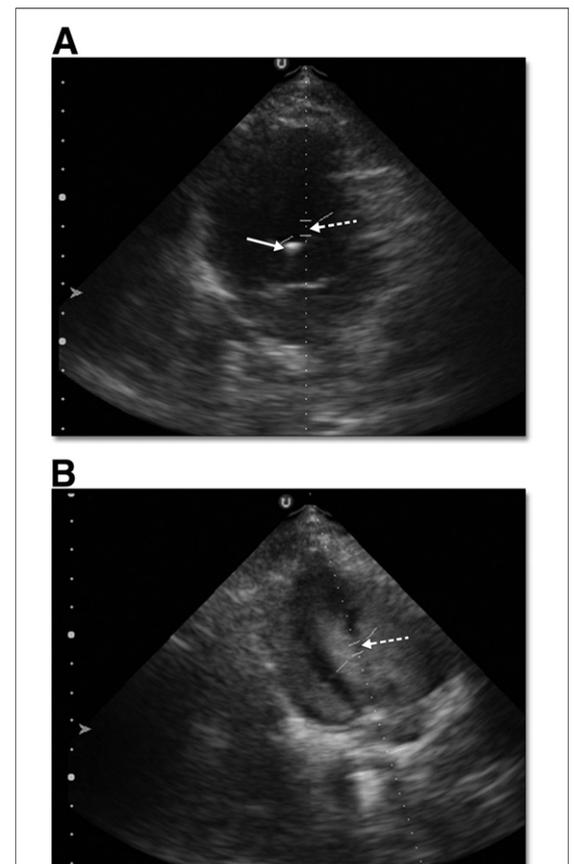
Ultrasound Data Acquisition
